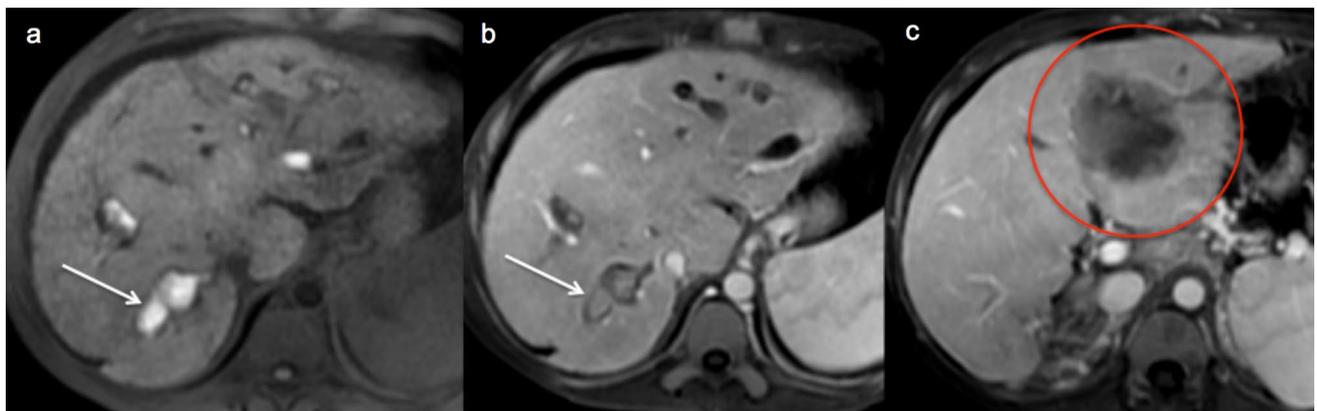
Caroli disease. MR imaging in patient with cystic dilations of the intrahepatic bile ducts containing stones on unenhanced T1-w and contrast-enhanced T1-w sequences (a, b) (white arrows). During
